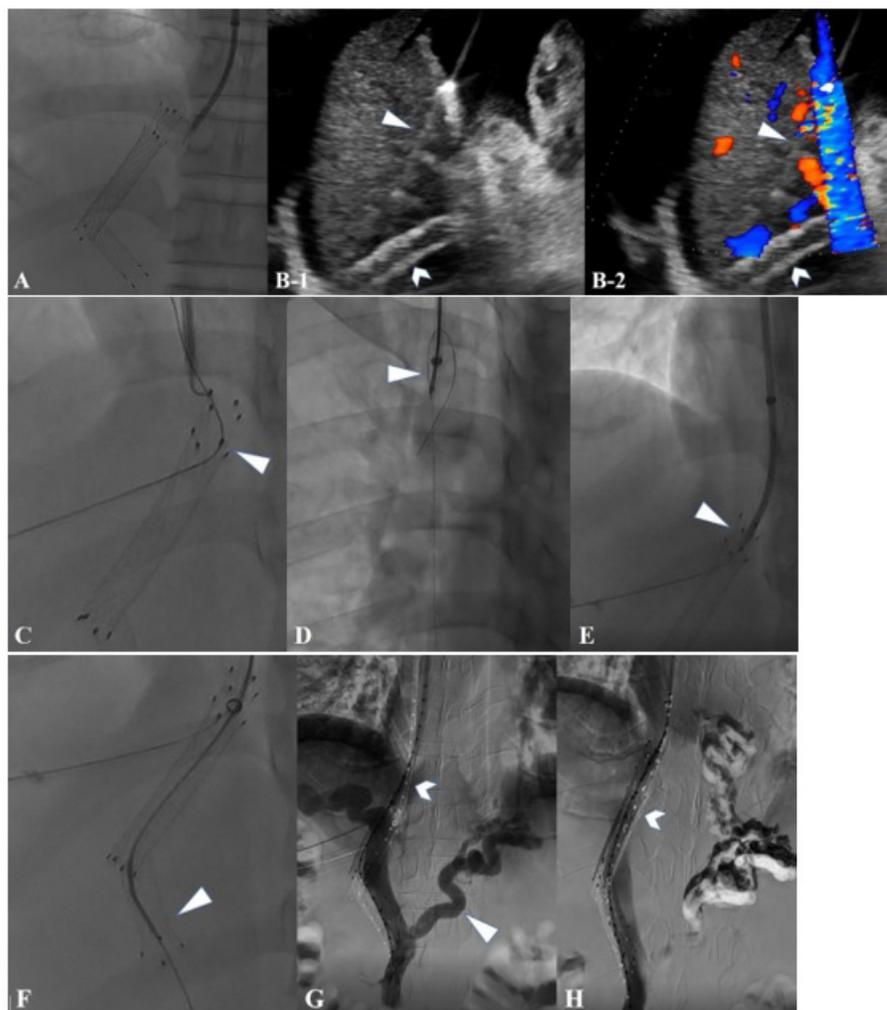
Percutaneous puncture of dysfunction shunt and revision. (A) Initial fluoroscopic image showed the wreckage of stents, and transjugular attempt of shunt entry failed. (B) Transabdominal ultrasound (US) image shows the percutaneous transhepatic needle (white triangle) positioned towards the shunt (white arrowhead) for placement guidewire. B-1: gray scale ultrasound imaging. B-2: color Doppler ultrasound imaging. (C) Once the needle punctures the stent, a 0.018 guidewire (white triangle) was advanced into the IVC through the needle. (D) Transhepatic guidewire was snared (white triangle) through the transjugular sheath, providing through-and-through access. (E) Transjugular sheath (white triangle) was advanced into the shunt over the transhepatic–transjugular wire. (F) Transjugular guidewire (white triangle) was maneuvered through the shunt (white arrowhead) into the main portal vein with a VER catheter. (G) Portography shows shunt occlusion (white arrowhead) with recurrent gastric varices (white triangle). (H) Fluoroscopic image of the shunt after GEVE and deployment of metal stents (white arrowhead) across tract between hepatic and portal vein.
